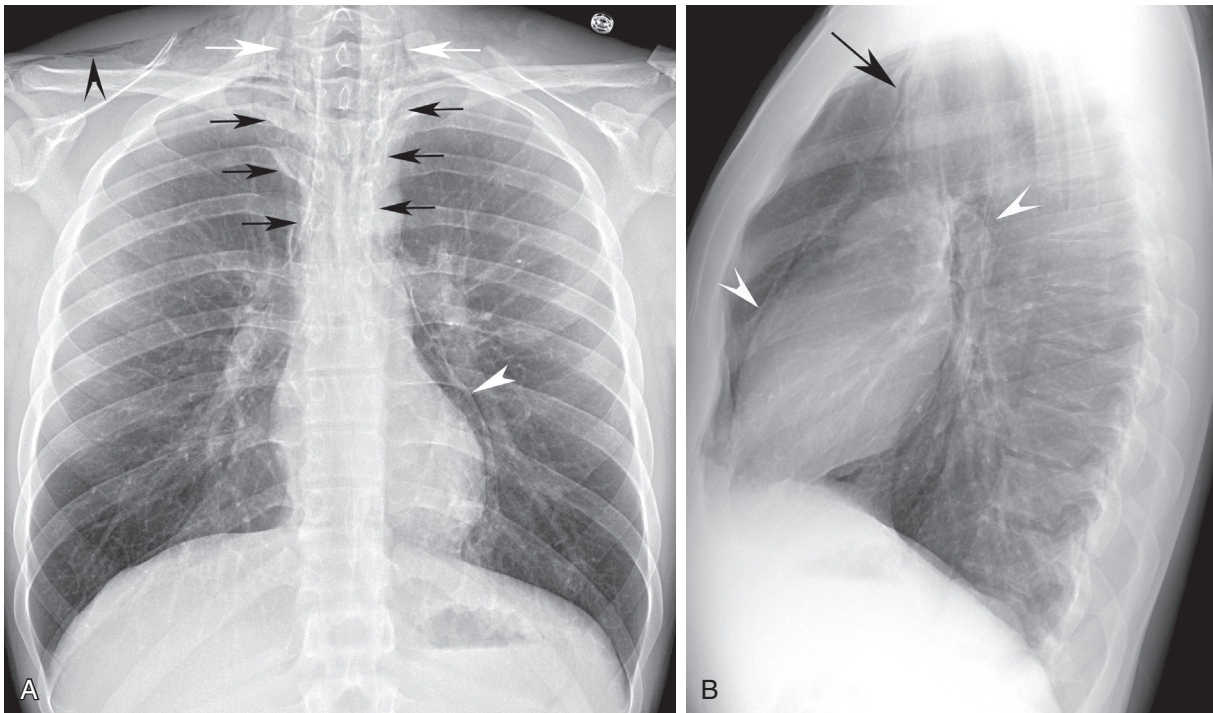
■ A, Posteroanterior (PA) upright chest x-ray. Pneumomediastinum (*black arrows*) extending into the base of the neck (*white arrows*) and right supraclavicular soft tissues (*black arrowhead*). Lucency is surrounding the heart due to a pneumopericardium (*white arrowhead*). B, Lateral upright chest x-ray. Pneumopericardium is surrounding the heart and left pulmonary artery (*white arrowheads*). Pneumomediastinum (*black arrow*) tracking upwards along the anterosuperior mediastinum.
